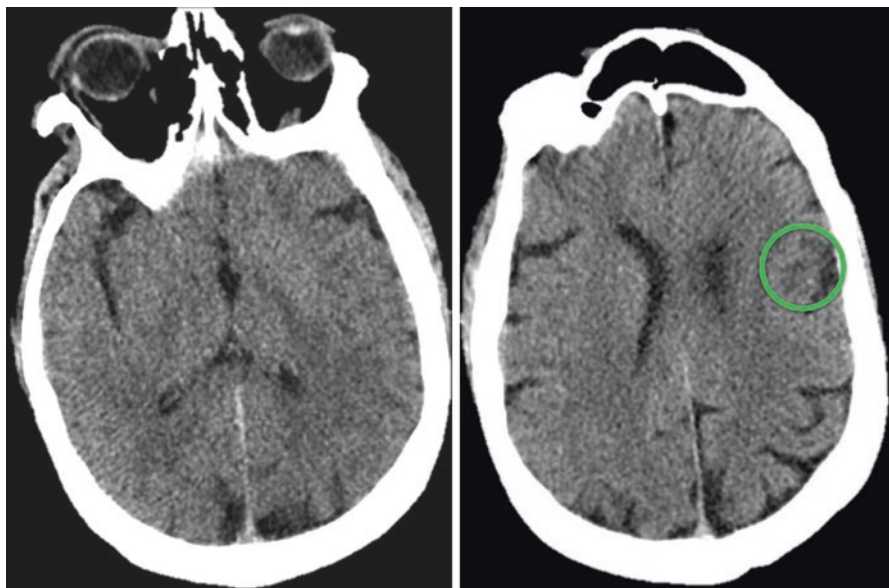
Axial images of non contrasted head CT. *Green circle* highlights small area of hypo density in the left frontal lobe. There are several possibilities as to the etiology of the hypodensity. None of which can explain the patient's presentation
